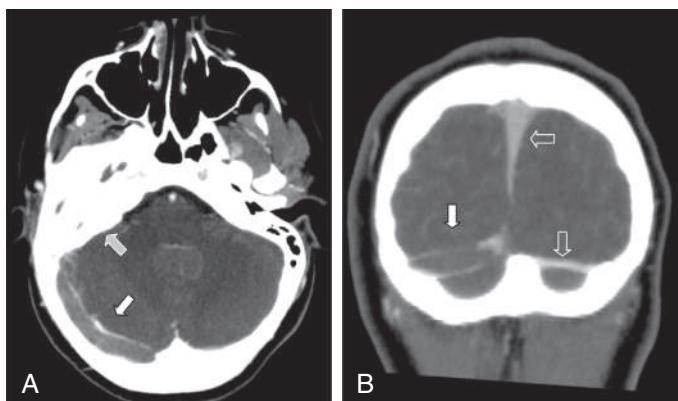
Cerebral sinovenous thrombosis. A 9-yr-old female presented with fever and progressive right-sided headache. She complained of double vision and had papilledema on examination. Axial (A) and coronal (B) CT venography demonstrates a large thrombus in the right transverse sinus that fails to opacify with contrast (solid arrows). Note normal filling in superior sagittal sinus and smaller left transverse sinuses (open arrows, right) and opacification of the mastoid air cells (hatched arrow, left). The cause was otitis media/mastoiditis with septic thrombophlebitis of transverse sinus.
